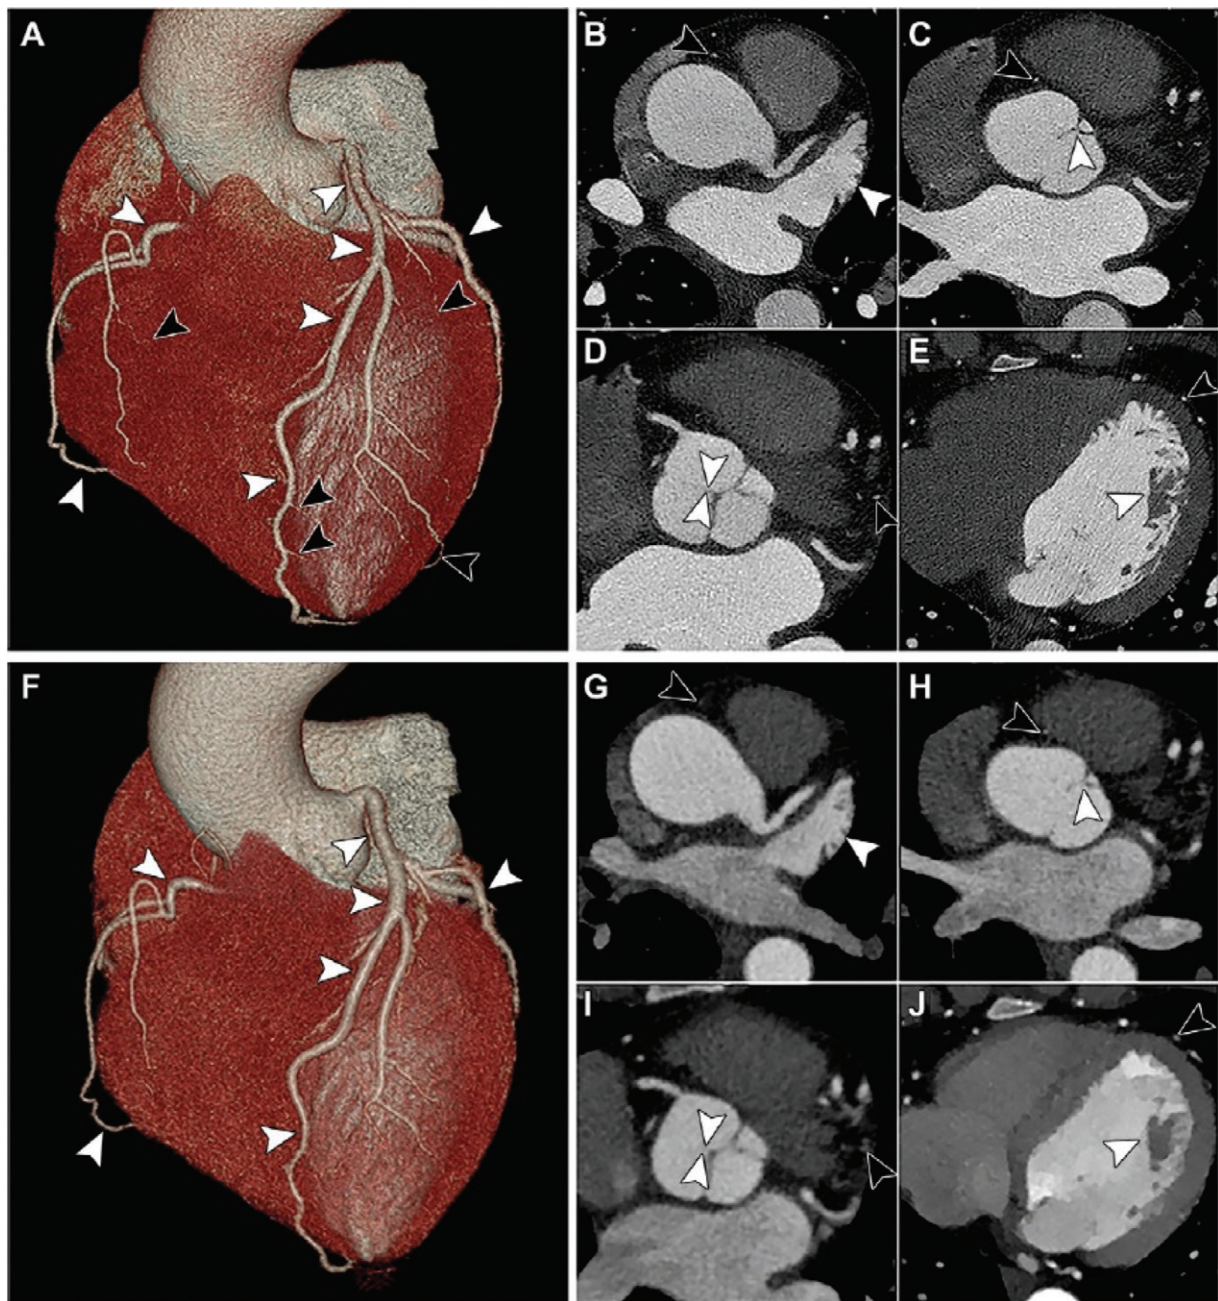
Examples of coronary imaging with photon-counting and dual-layer CT. (A–E) Coronary photon-counting CT scans and (F–J) dual-layer CT angiograms in a 44-year-old woman with normal coronary morphologic characteristics and cardiac anatomy. (A, F) Volume-rendered images from photon-counting CT (A) and CT (F) show proximal coronary arteries (white arrowheads in A and F); however, the distal segments of coronary arteries are better depicted on photon-counting CT (black arrowheads in A) compared with CT images. On axial images, pectinate muscle (B, G), aortic cusp commissure (C, H), noncoronary cusp (D, I), and papillary muscle (E, J) were better depicted on photon-counting CT images (B–E) than on CT images (G–J) (white arrowheads). The depiction of the distal segment of coronary arteries on axial images is better on photon-counting CT images than on CT images (black arrowheads).
